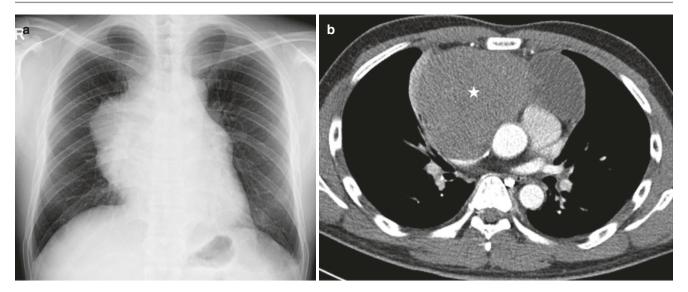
41-year-old man with anterior mediastinal B-cell lymphoma. (a) Frontal radiograph shows a large mass in the mediastinum, silhouetting the right and left heart borders but without silhouetting the aortic knuckle. The descending aorta can be seen through it. Visualization of the right pulmonary artery represents "hilum overlay"
